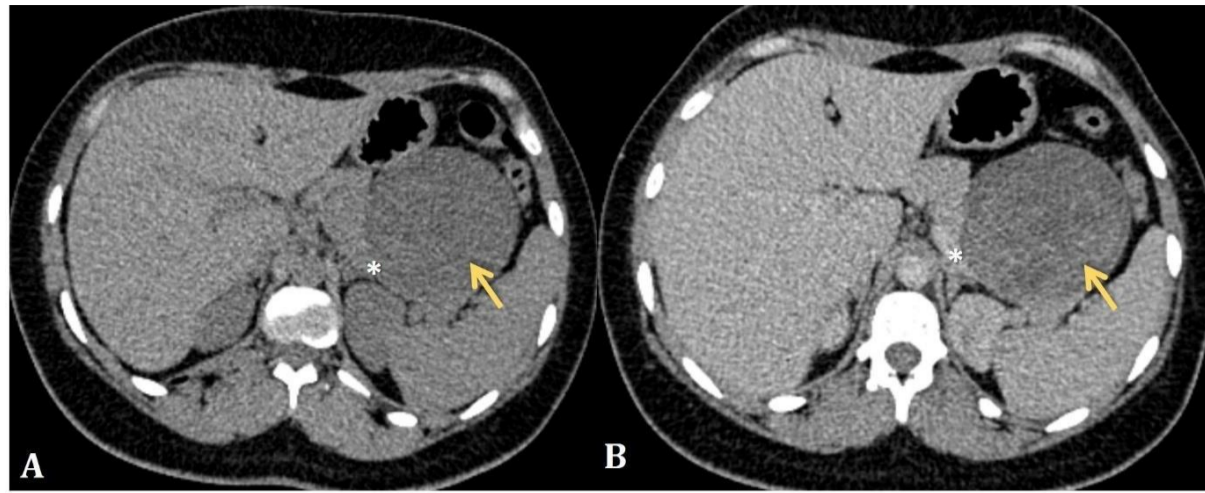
Axial non-enhanced (A) and post-contrast (B) abdominal CT images demonstrating a well-encapsulated mixed density lesion (yellow arrow) of the pancreatic tail (asterix), with cystic central component and peripheral hyperdense solid portion that slightly enhances on post-contrast images.
